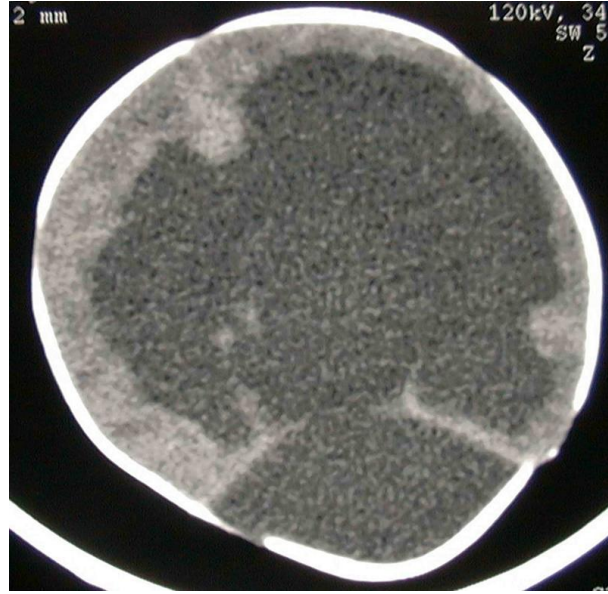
Axial cranial CT shows enlarged ventricular system, disappearance of sulcus and gyrus discrepancy, fusion in parenchyma's and basal ganglia and cerebellar aplasia.
